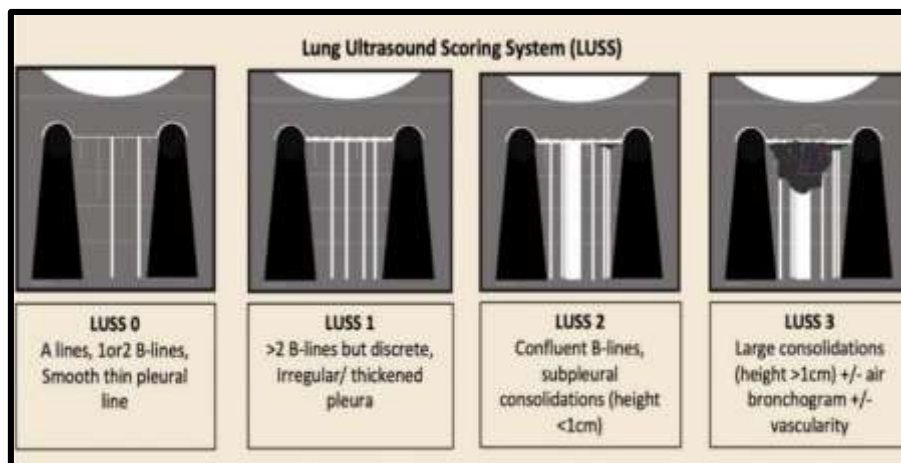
Lung ultrasound scoring system (LUSS) points range from 0 to 3, with higher points allocated to severe lung changes. Based on the total score from 12 lung zones, the severity classified as mild (score 1-5), moderate (>5-15) and severe (>15). A normal lung will have a total score of 0
